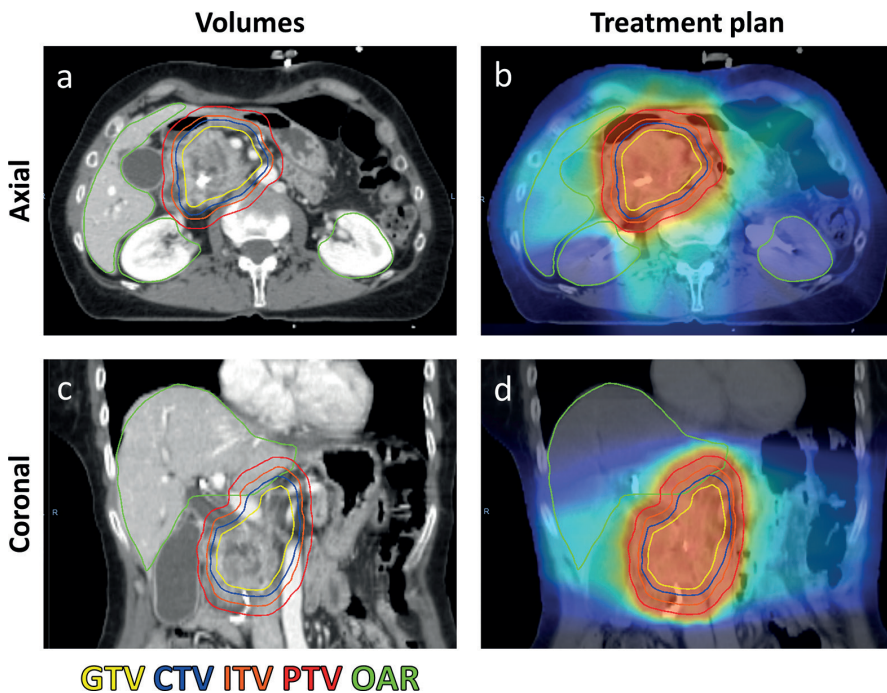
Delineated GTV (yellow), CTV (blue), ITV (orange) and PTV (red) volumes, as well as some OARs (liver + kidneys; green) projected on a planning CT scan in axial (a) and coronal (c) view. Treatment plans based on these delineated volumes are presented too (b, d).
